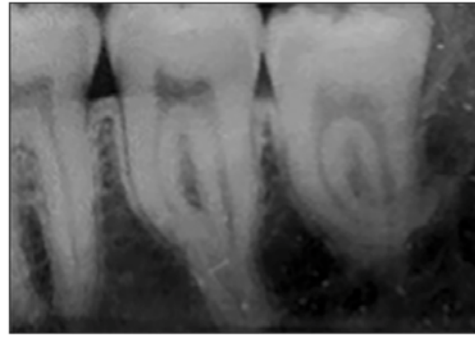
Periapical radiograph of root dilaceration #17 and #18.
